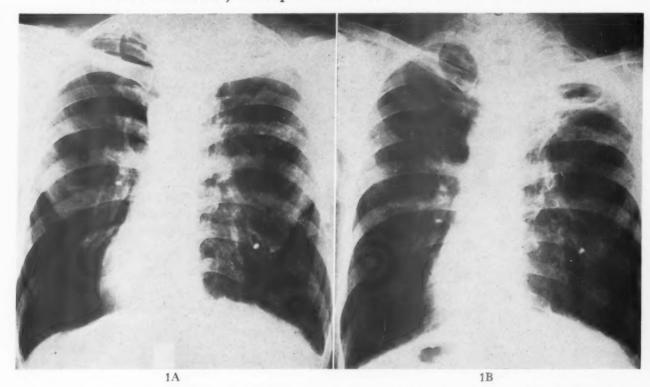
Case i. A, chest roentgenogram taken May 4, 1949, showing bilateral emphysema, calcification and right apical infiltration with cavitation. B, chest roentgenogram taken June 9, 1952, showing enlargement of right apical cavitary lesion and bilateral emphysema. These and the subsequent films are anteroposterior views.
